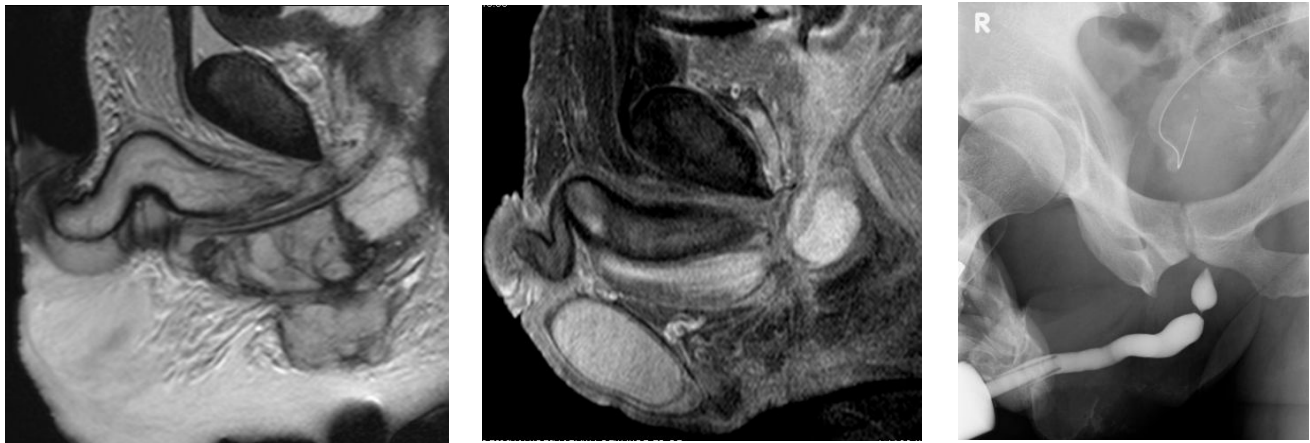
Sagittal T2-weighted (a) of acute phase injury (1 day after the injury). Hematoma surrounding bulbar urethra (white arrow). Sagittal contrast-enhanced T1-weighted image (b) of the same patient after 5 months show short-segment fibrosis. Retrograde urethrogram (c) also shows short-segment stricture.
